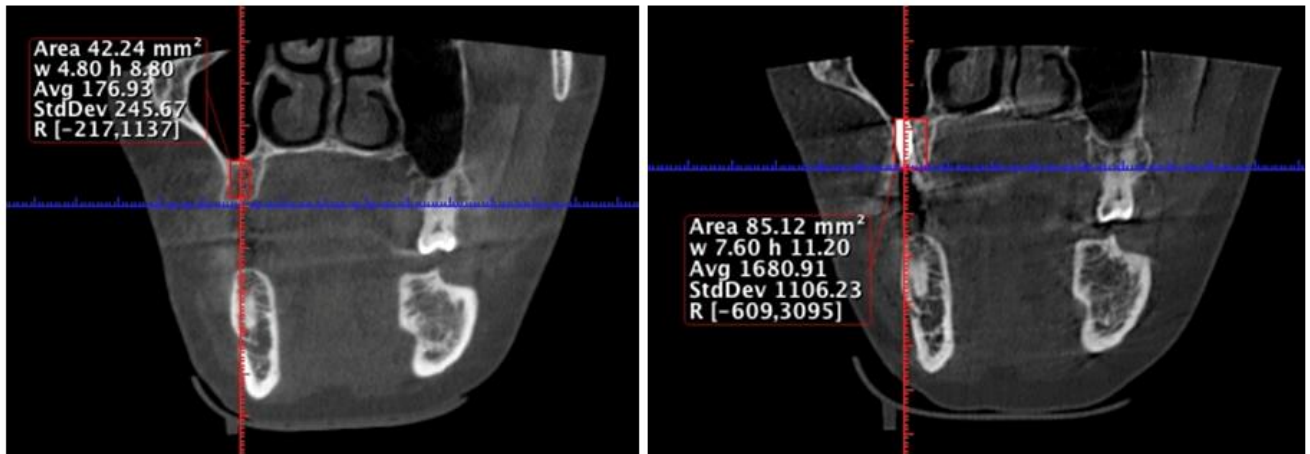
Pre (left) and post-operative (right) CBCT scans for the same patient showing the increase in alveolar bone height after 6 months.
